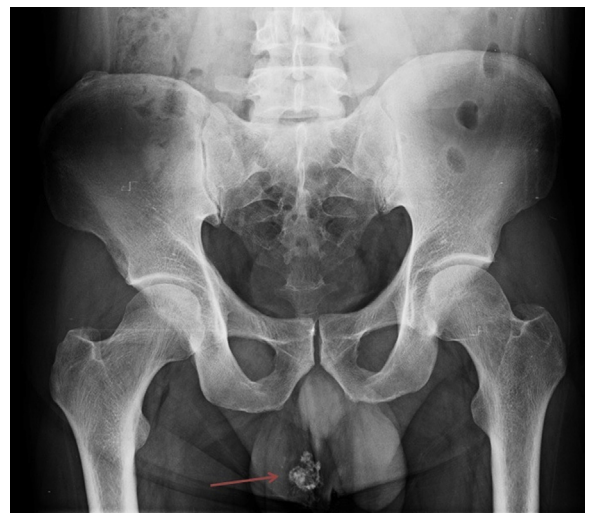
Plain X-ray finding incidental right testicular macrocalcification, which lead to diagnosis. Arrow pointing at calcifications.
